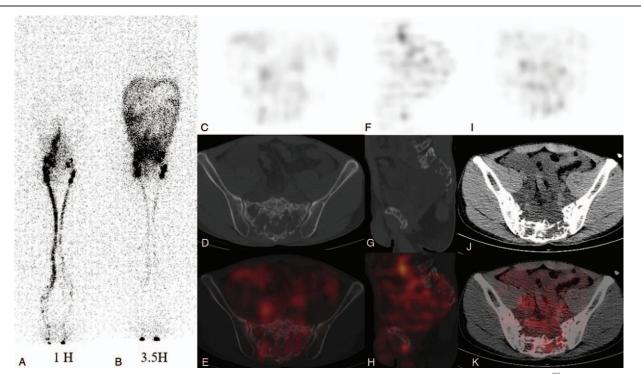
Representative images of Gorham–Stout disease in patient 2. (A) Anterior image of lymphoscintigraphy obtained 1 h after ^{99m}Tc-ASC injection; (B) anterior image of lymphoscintigraphy obtained 3.5 h after ^{99m}Tc-ASC injection; (C–E) Axial SPECT, CT, and fusion images of the pelvis (bone window); (F–H) sagittal SPECT, CT, and fusion images of the pelvis (bone window); (F–H) sagittal SPECT, CT, and fusion images of the pelvis (bone window); (I–K) axial SPECT, CT, and fusion images of the pelvis (soft-tissue window).
